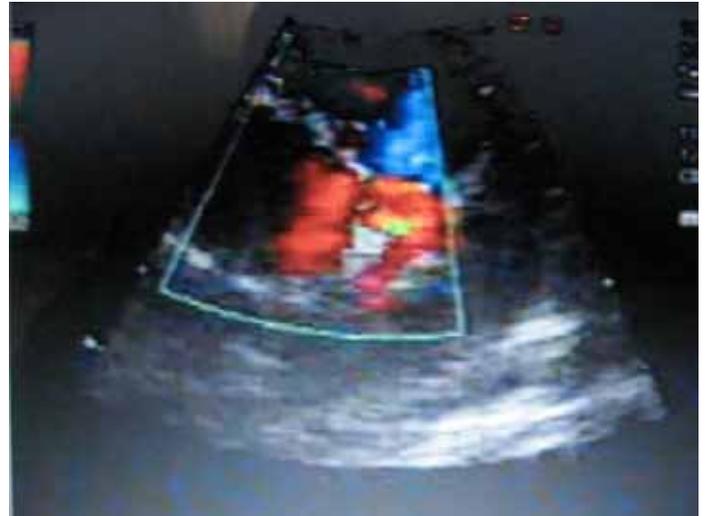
A trans-thoracic echocardiogram with retrograde flow (in red) through the patient's left coronary into the pulmonary artery.
